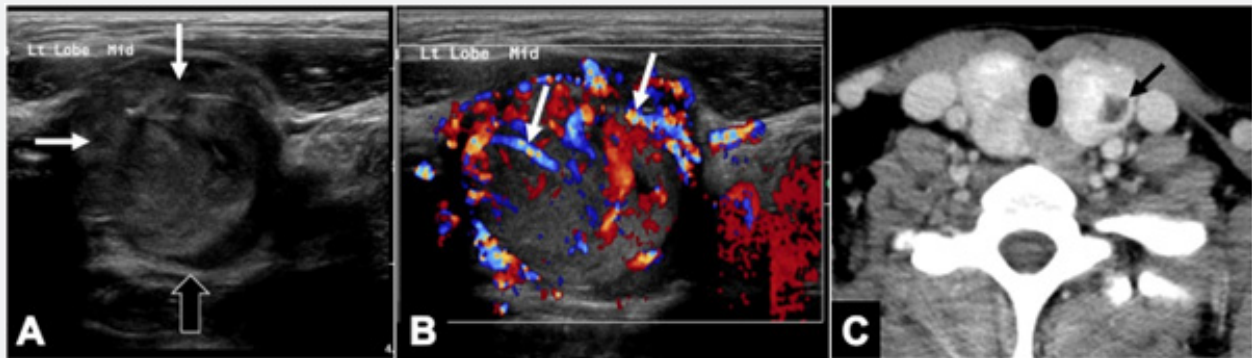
Classic variant, follicular thyroid carcinoma in a 29-year-old female. Transverse US (a) image of the left thyroid lobe shows fairly defined mass of heterogenous slightly isoechoic echotexture (arrow), and loss of well-defined surrounding hypoechoic halo. Transverse color Doppler (b) image shows type 4 flow pattern, peripheral ring with intense internal vascularity “green arrows”. Axial contrast-enhanced CT (c) image demonstrates ill-defined iso-dense mass with internal areas of necrosis (black arrow).
